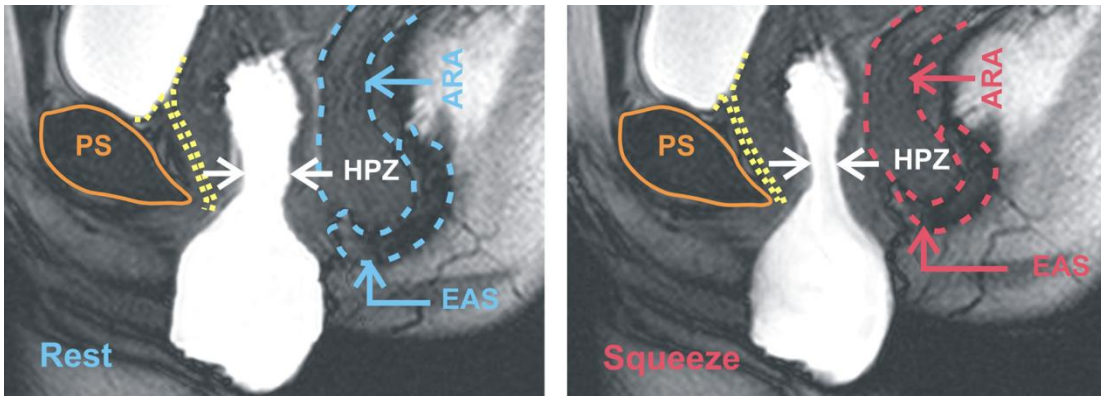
MRI images of pelvic floor with intra-vaginal water bag. Constriction (white arrows) on the bag represents Vaginal HPZ (high pressure zone). It is located between the anal canal (broken red and blue lines) and urethra (broken yellow lines). Distance moved by ARA (anorectal angle) in cranial direction is similar to movement of posterior pressure cluster on HDM. EAS: External anal sphincter, PS:Pubic symphysis.
